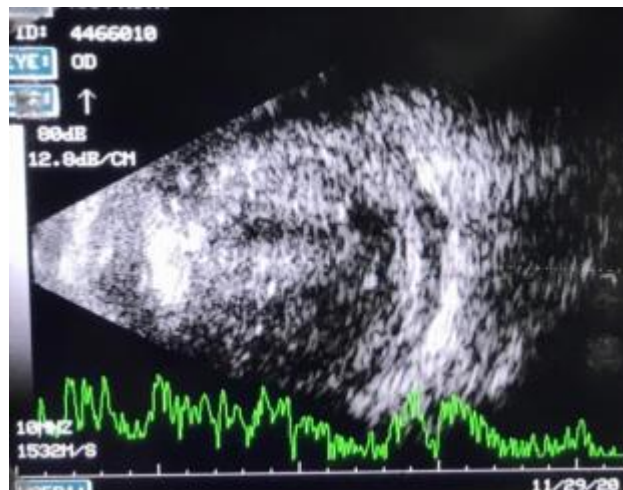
Ultrasonography of the right eye in RSCM Kirana. The B-scan showed diffuse intraocular mass from anterior-posterior vitreous with shadowing effect. A-scan spikes showed hyperechoic profile of the mass. The USG suggestive of hyperechoic intraocular mass suspected of later stage of retinoblastoma.
